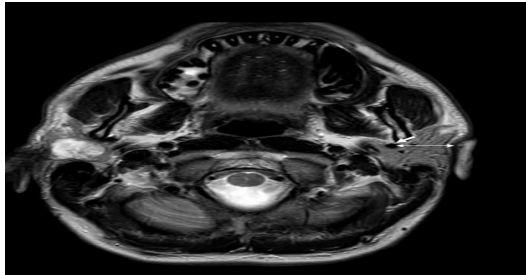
Axial T2-weighted image demonstrating the parotid gland anatomy and retromandibular vein localization.
